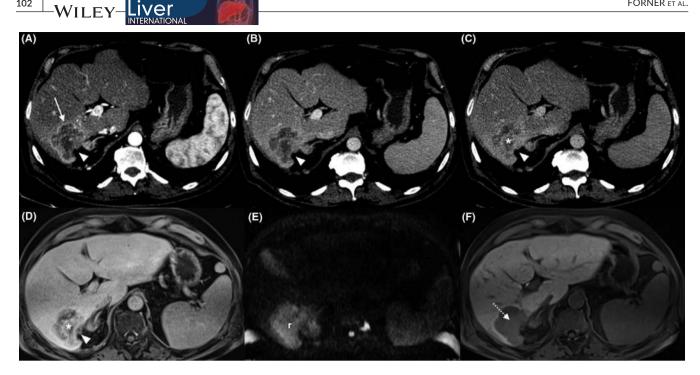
Role of CT and MRI imaging in iCCA. The typical vascular behaviour of iCCA can be appreciated on CT images (A, B, C). Peripheral arterial enhancement (arrow), capsular retraction (arrow head) and late enhancement (asterisk) represent typical imaging features of iCCA. MRI images (D, E, F) demonstrate the same vascular features of CT with the added value of diffusion weighted images (E), showing a marked restriction (r) and the hepato-specific phase (F), showing the absence of the uptake of hepato-specific contrast medium (dotted arrow)
